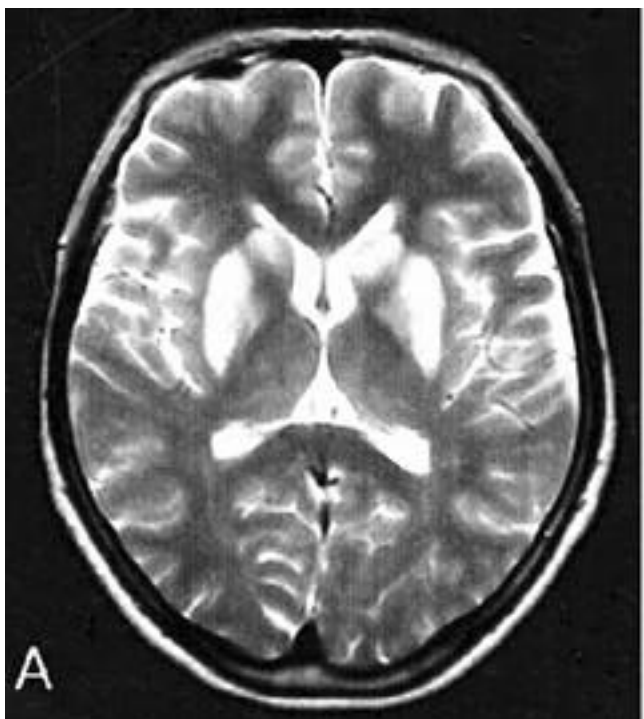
The brain MRI taken after development of parkinsonian features. A. There is a bilateral increased T2-signal intensity in pallidostriatum. B. There is a bilateral slight increased T1-signal intensity in putamen and pallidum with a focal decreased T1-signal intensity in left putamen.
